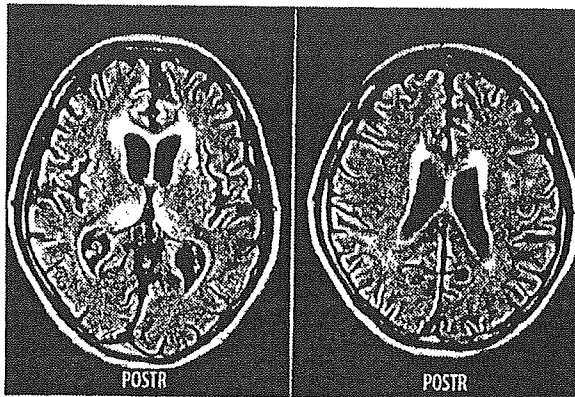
MRI T2WI revealed high intensity lesions in both thalami and deep white matter (arrows).
